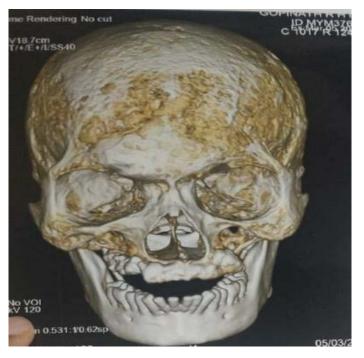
CT 3D Reconstruction
